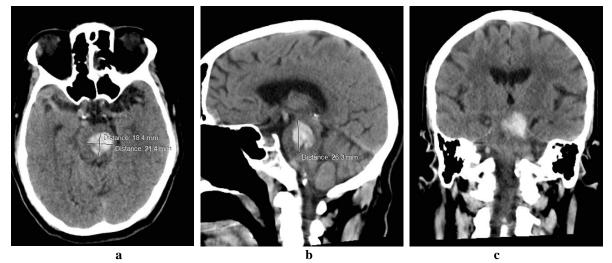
a, b & c: CT scan of brain axial, sagittal & coronal images of a 60 years aged male showing brainstem hemorrhage
